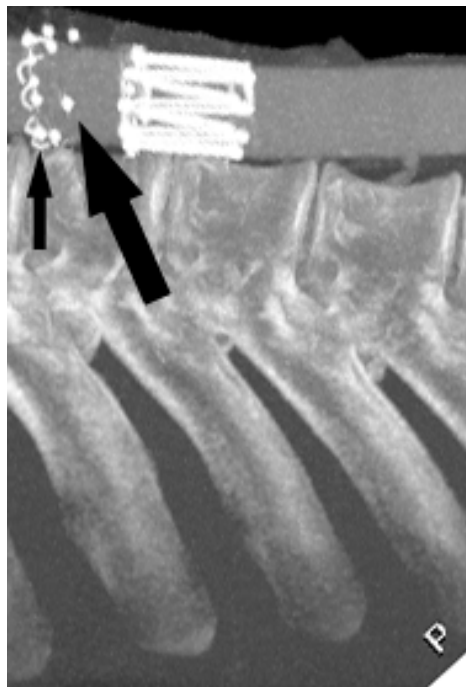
3D maximum intensity projection of the CT image of the thoracic aorta. Small arrow lower left: nitinol clip; large arrow right: tantalum marker. Cranial side to the left.
